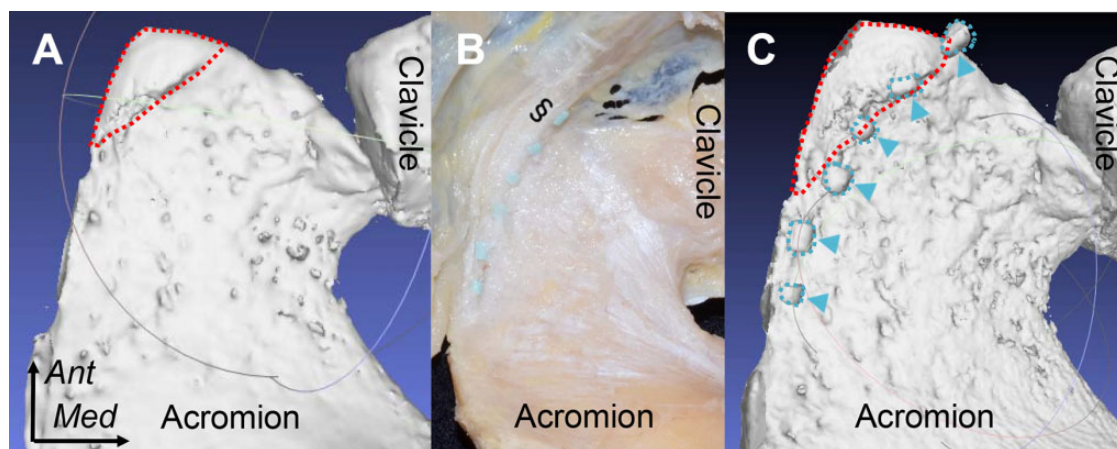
(A) Location of the prominence at the anterolateral acromion (red dotted area), which has a posterior margin from the anteromedial corner of the acromion near the acromioclavicular joint to the lateral edge of the acromion with the posterior curve. (B) Placement of radiopaque markers at the medial border of the coracoacromial ligament. (C) Plain 3-dimensional computed tomography image showing correspondence between the markers (blue arrows) and the medial border of the anterolateral prominence of the acromion (red dotted area). Ant, anterior; Med, medial.
